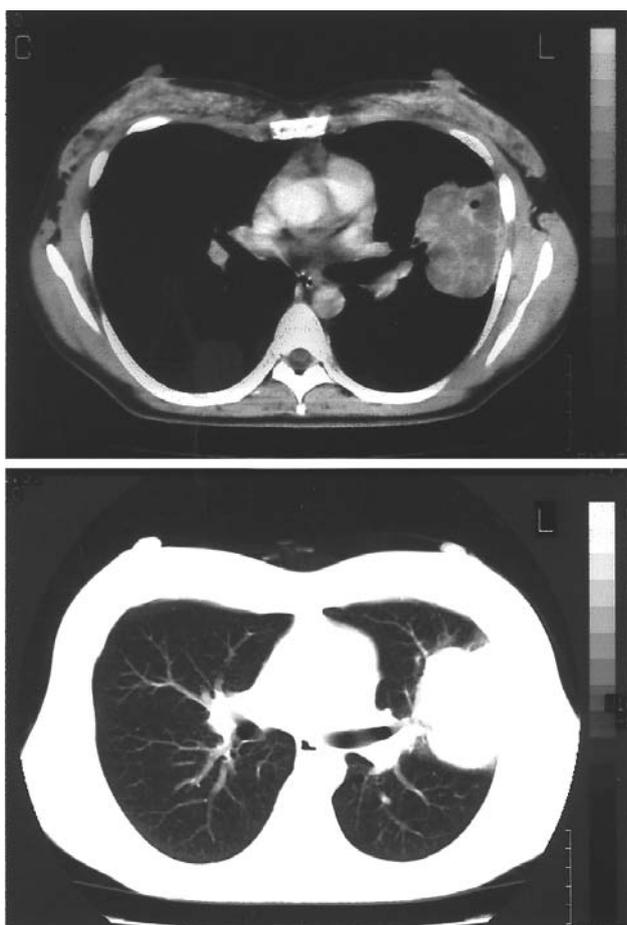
Computed tomography of the chest in our patient disclosed an 8 x 6 cm lung mass in the left upper lobe without enlargement of intrapulmonary or mediastinal lymph nodes.
